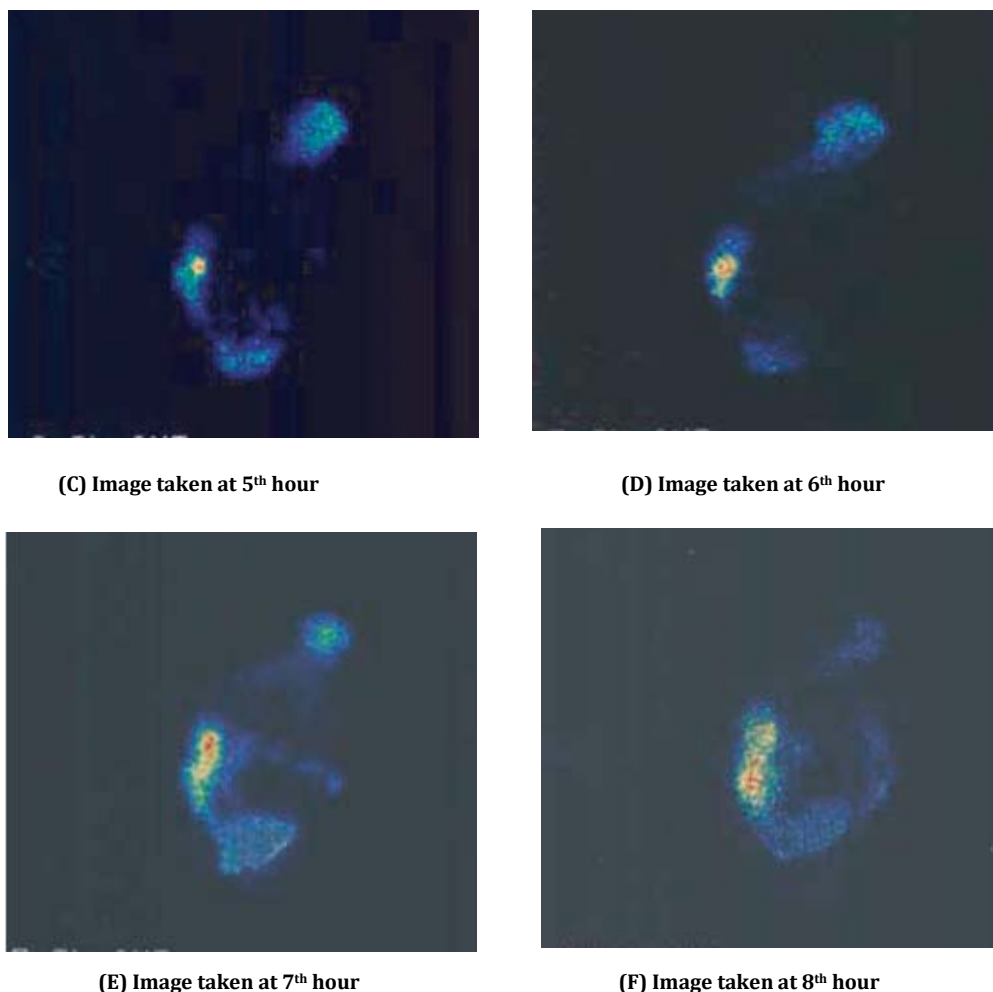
Gamma-scintigraphic studies
